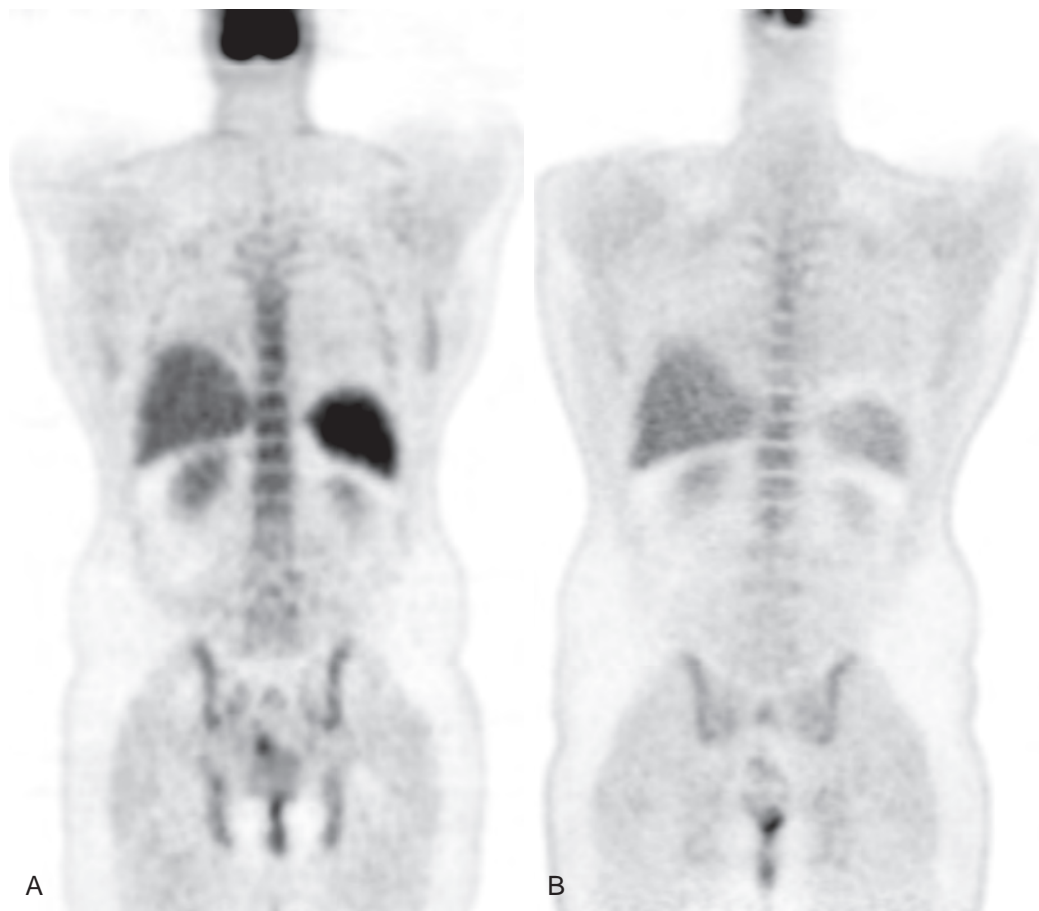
Splenic lymphoma. A. PET scan demonstrated abnormal increased FDG avidity in the spleen compared with the liver, consistent with lymphoma. B. PET scan 1 month after chemotherapy demonstrates resolution of increased FDG avidity consistent with treatment response.
